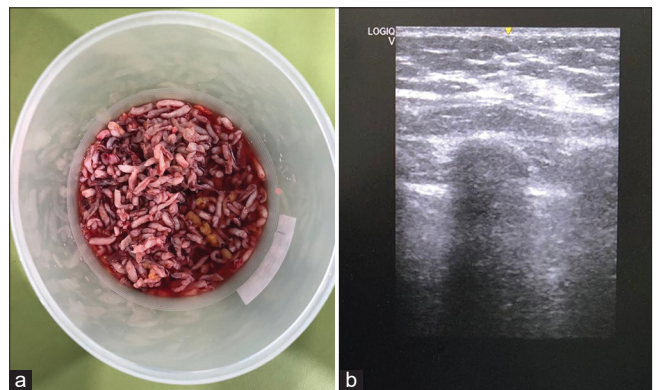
(a) The sliced mass after vacuum-assisted breast biopsy (VABB), (b) the ultrasound on the right breast after VABB
